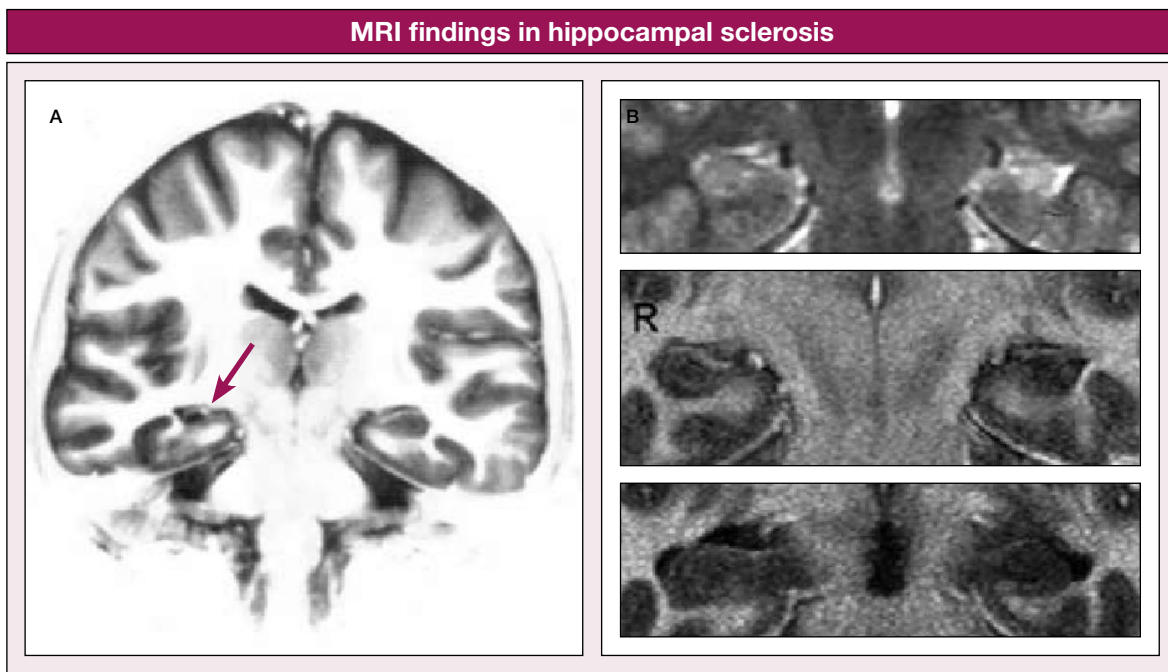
(A) Coronal T1-weighted MRI scan showing right hippocampal sclerosis (arrow). (B) Coronal T2-weighted and magnified T1-weighted MRI scan showing left hippocampal sclerosis.
